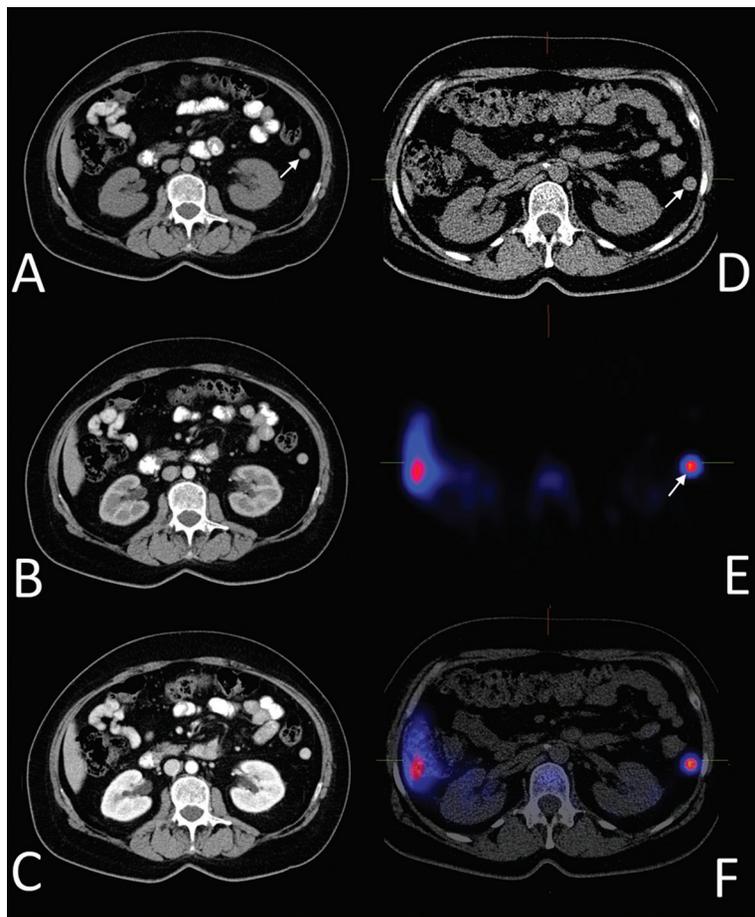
Patient 1. A, B, C. Multi-phase computed tomography (CT): pre-contrast, arterial and delayed phases, respectively. Axial scans. Accessory spleen located below the main spleen (arrow); D, E, F. Radionuclide study: CT, pure single photon emission computed tomography (SPECT) and fused SPECT/CT images. Axial scans. Radiotracer uptake confirming accessory spleen.
